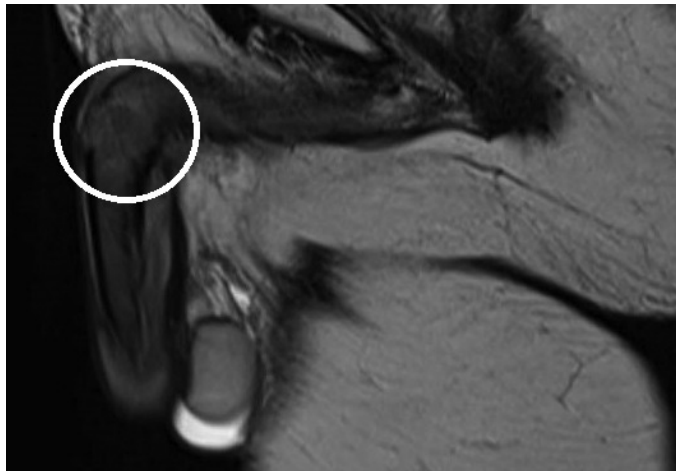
MRI image of the left cavernous body with a suspected lesion at referral (white circle)
